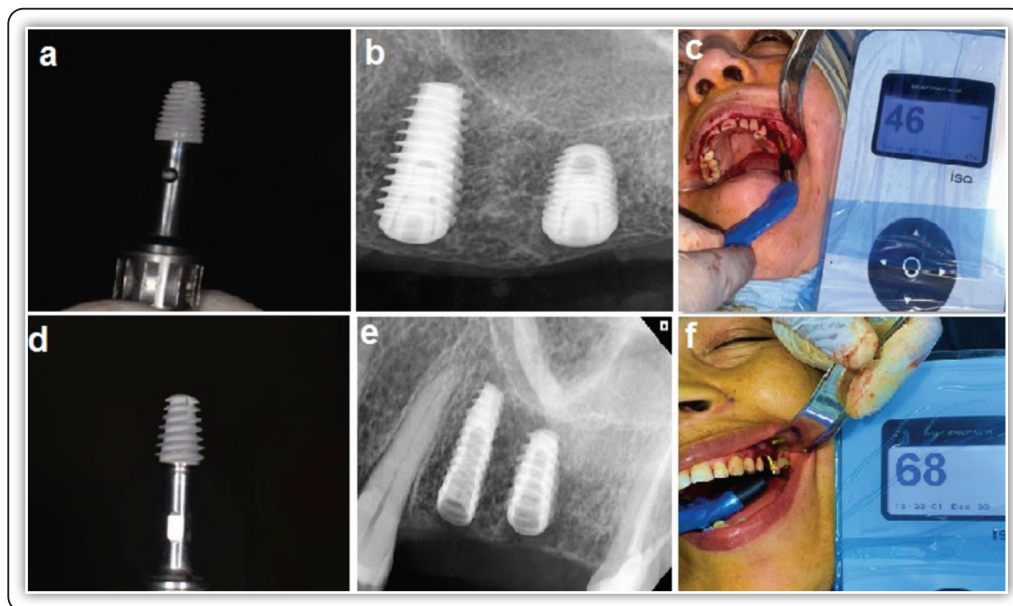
(a, b) conventional threaded implant clinical and Radiographical photo (C) conventional threaded implant stability (d, e) deep threaded implant clinical and radiographic photo (e) deep threaded implant stability
